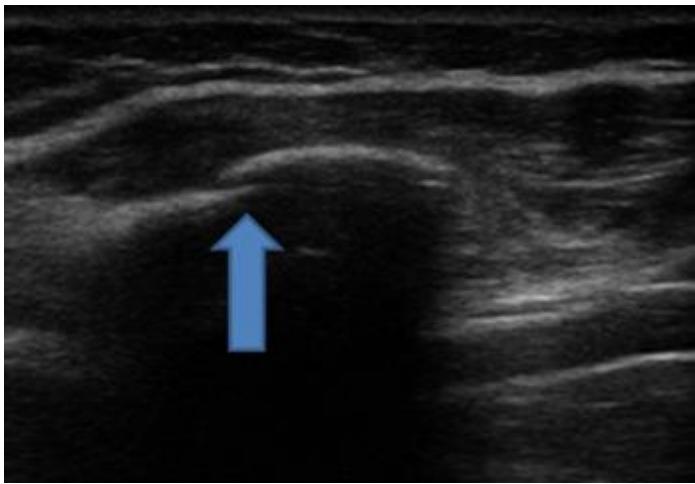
Ultrasound image showing cortical bone fracture (Courtesy of Giles N. Cattermole, BM BCh).
